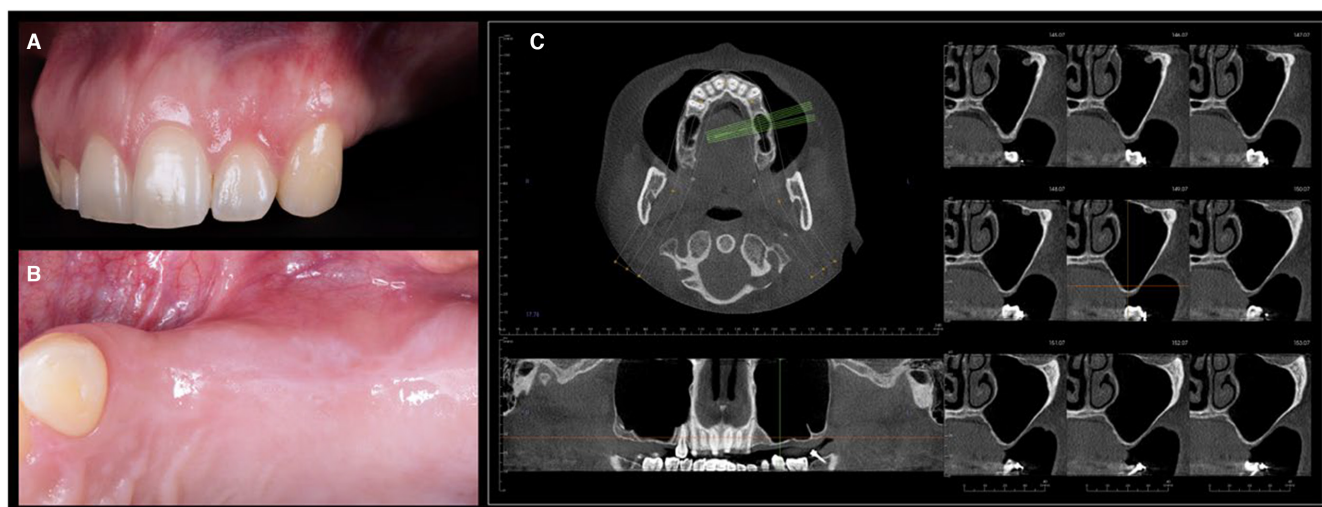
Oblique (A) and occlusal (B) intraoral photographs, and cone-beam computed tomography imaging (C) of the upper left region of a patient presenting bilateral bone atrophy associated with posterior maxillary edentulism. (Adapted with permission from Avila-Ortiz et al.¹).
